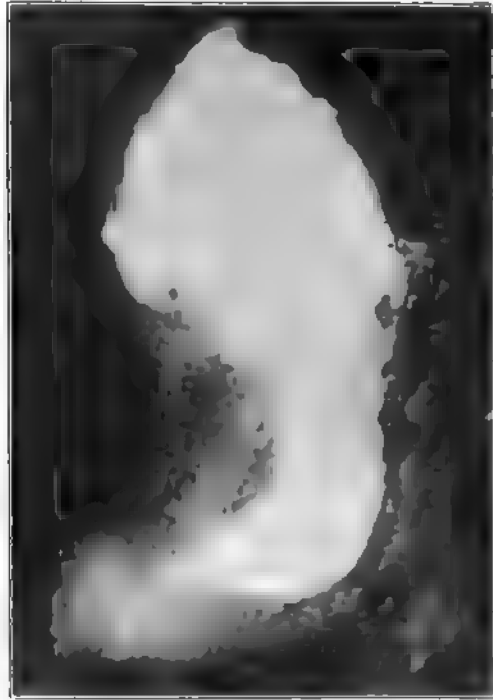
Stomach removed postmortem, filled with bismuth, and radiographed. Note thickness of walls and narrowing of lumen due to the invasion of a colloid carcinoma. It gives a radiogram such as is shown in Fig. 41.
